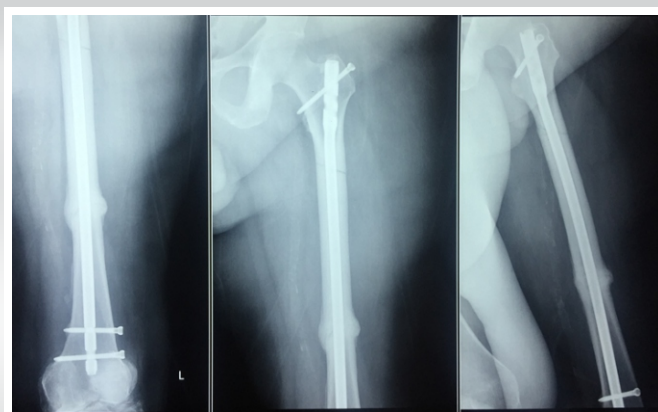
X-ray image showing early healing of the second subtrochanteric femoral fracture, 2-3 months after diagnosis and conservative management. The fracture shows signs of consolidation following a period of non-weight-bearing and gradual resumption of weight-bearing activities.
